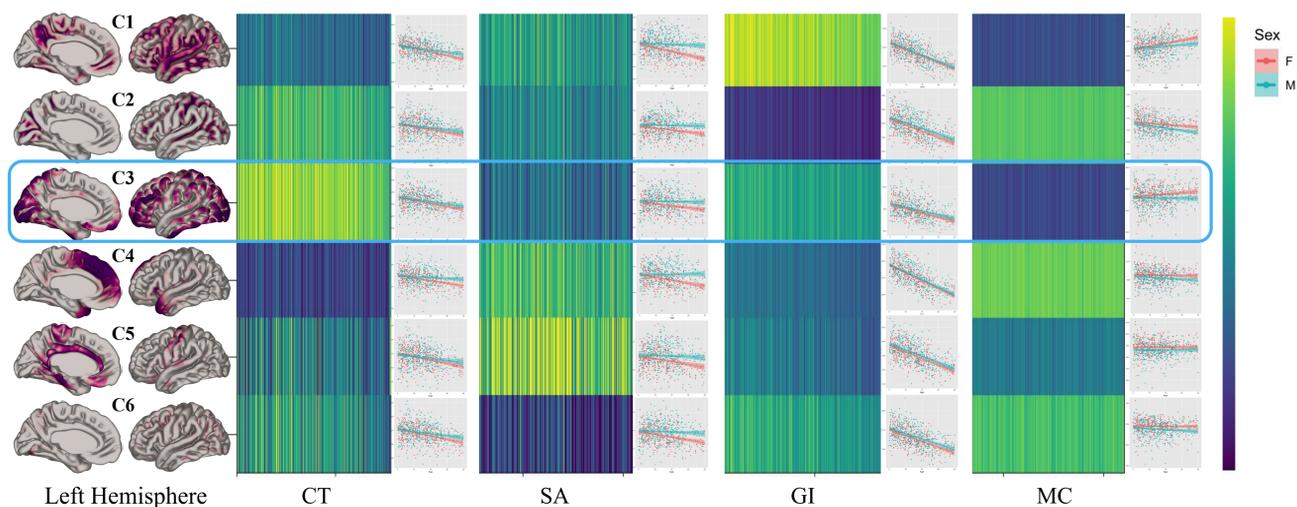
The components and weight matrix together show the component-specific description with respect to multiple measures in each of the spatial components. e.g., C3 corresponds more heavily to weight on a high CT, moderate SA and GI, but low MC. (in blue) Weightings of all components significantly decreased with age and were significantly greater in males compared to females across morphometric measures ($q < 0.05$), except for MC components; significant age and sex interactions ($q < 0.05$) were observed across SA weightings such that males show a slower SA loss relative to females.
